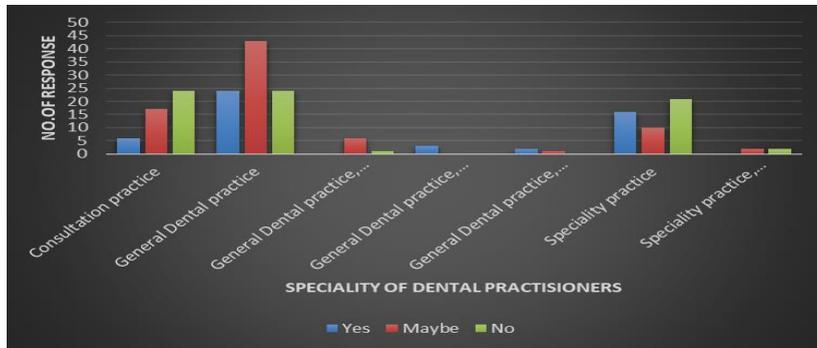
depicts the recommendation of a CBCT scan for children below 18 years of age.
